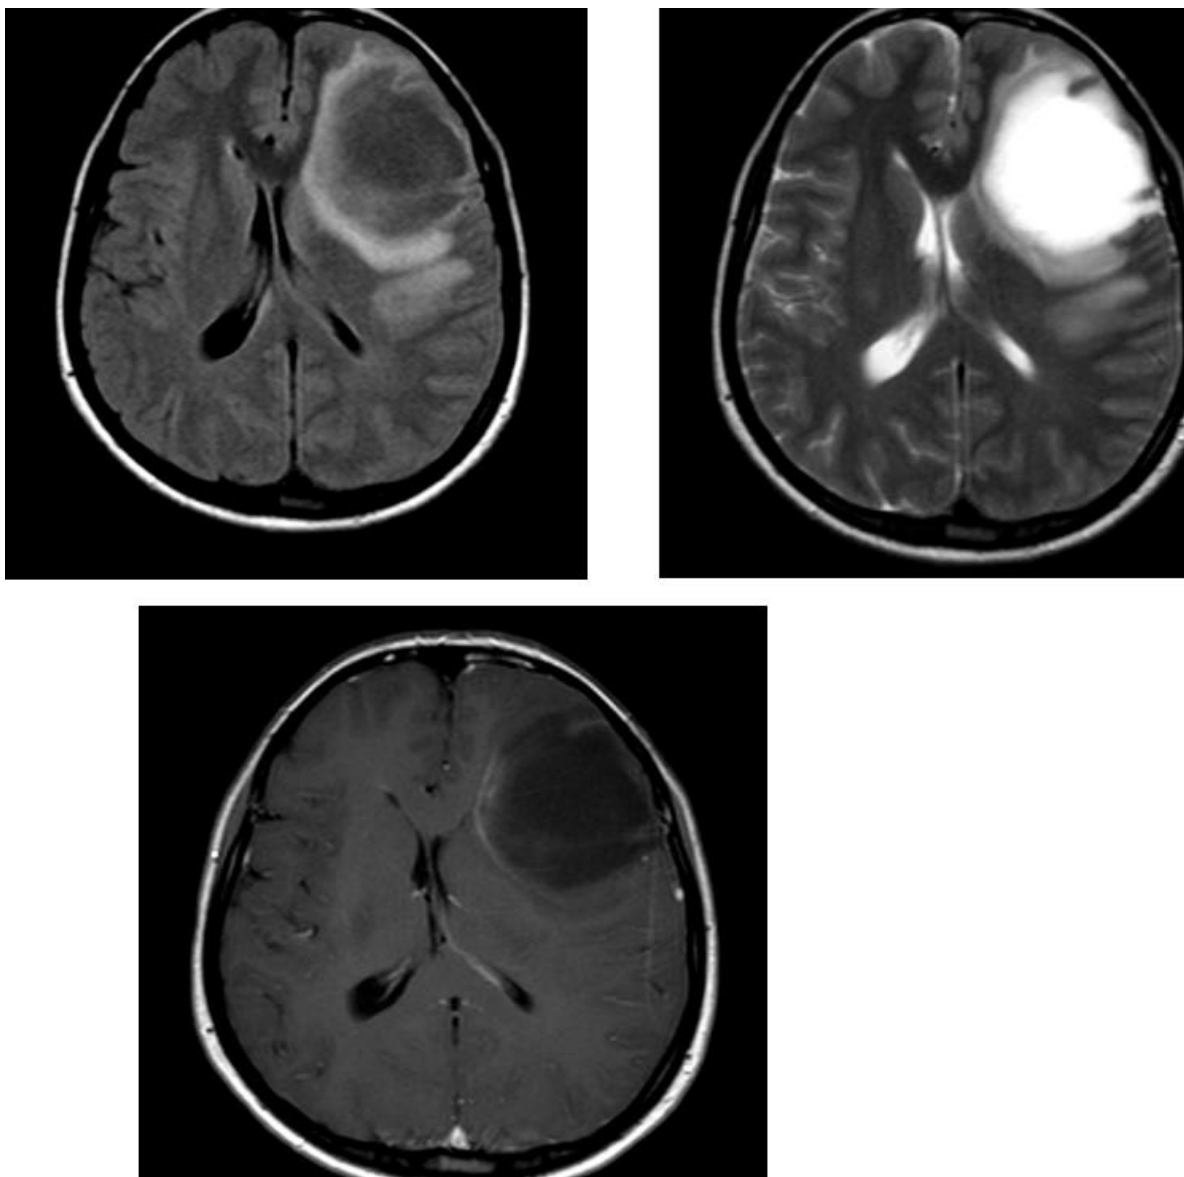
Tumefactive demyelination in left frontal lobe showing partial suppression on FLAIR and incomplete or ring enhancement
